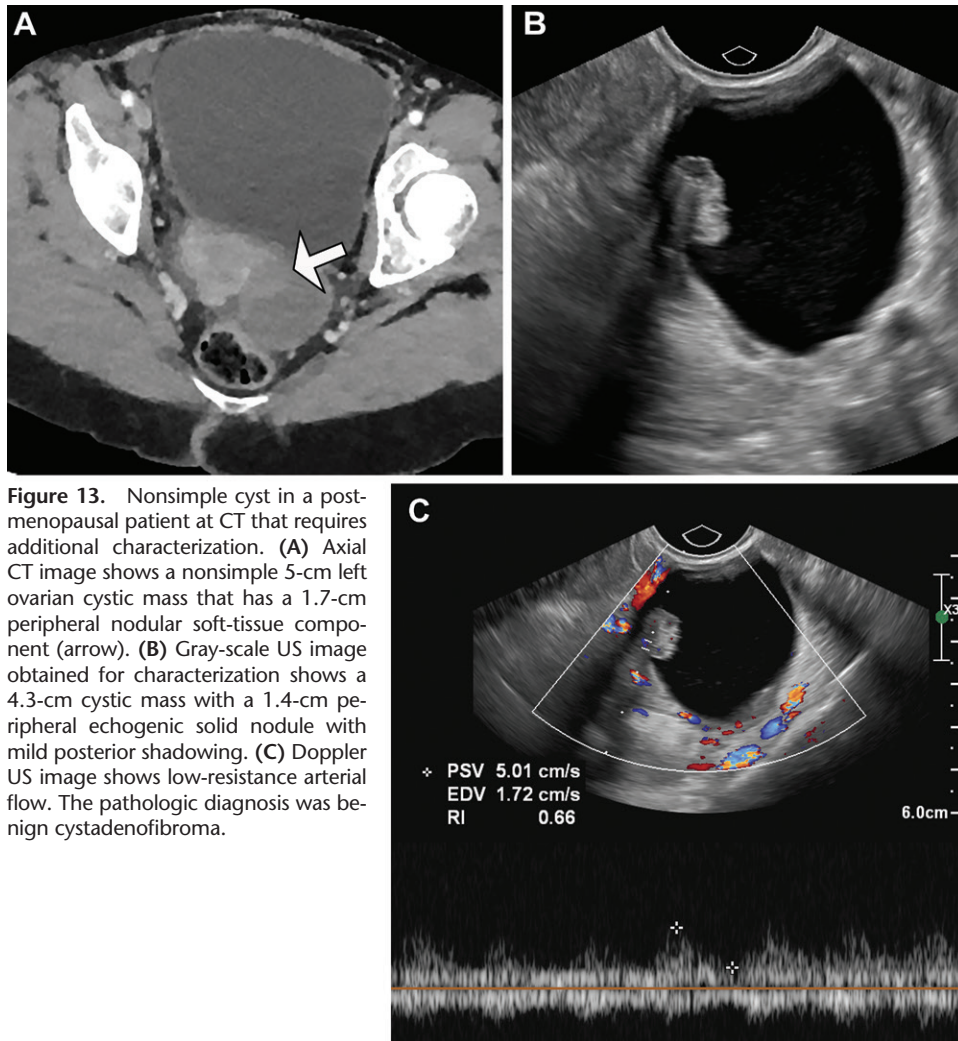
Nonsimple cyst in a postmenopausal patient at CT that requires additional characterization. (A) Axial CT image shows a nonsimple 5-cm left ovarian cystic mass that has a 1.7-cm peripheral nodular soft-tissue component (arrow). (B) Gray-scale US image obtained for characterization shows a 4.3-cm cystic mass with a 1.4-cm peripheral echogenic solid nodule with mild posterior shadowing. (C) Doppler US image shows low-resistance arterial flow. The pathologic diagnosis was benign cystadenofibroma.
